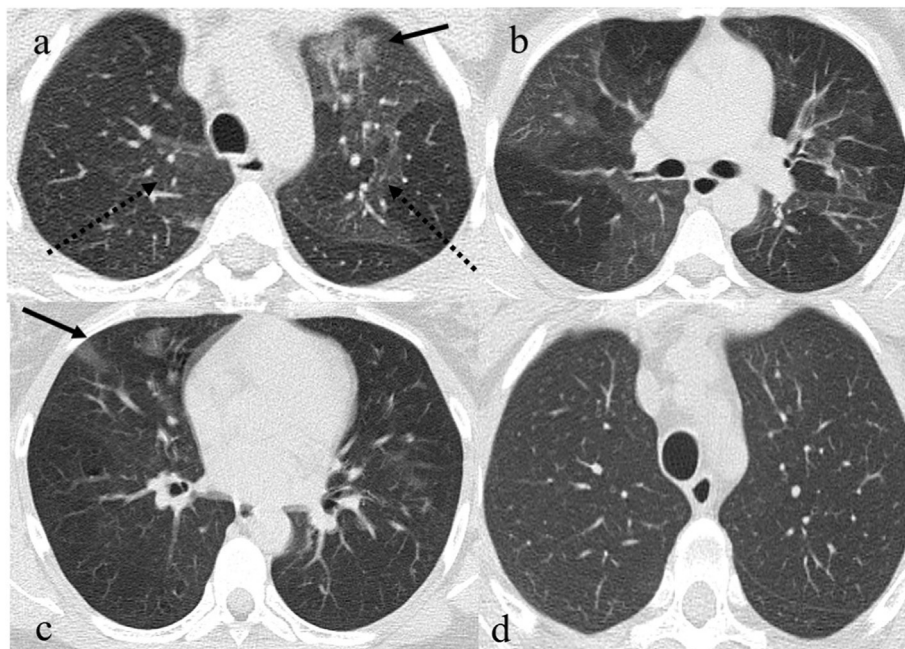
Chest CT scan of the third patient describing GGOs with a peripheral distribution (black arrow) and also a peribroncovascular distribution (black dotted arrows) in the superior lobes (a); GGOs with a peripheral, posterior distribution and also a peribroncovascular distribution in the superior and inferior lobes (b); GGOs with a peripheral distribution in the right middle lobe (c); resolution at 20 days after therapy of the previous GGOs in the superior lobes.
